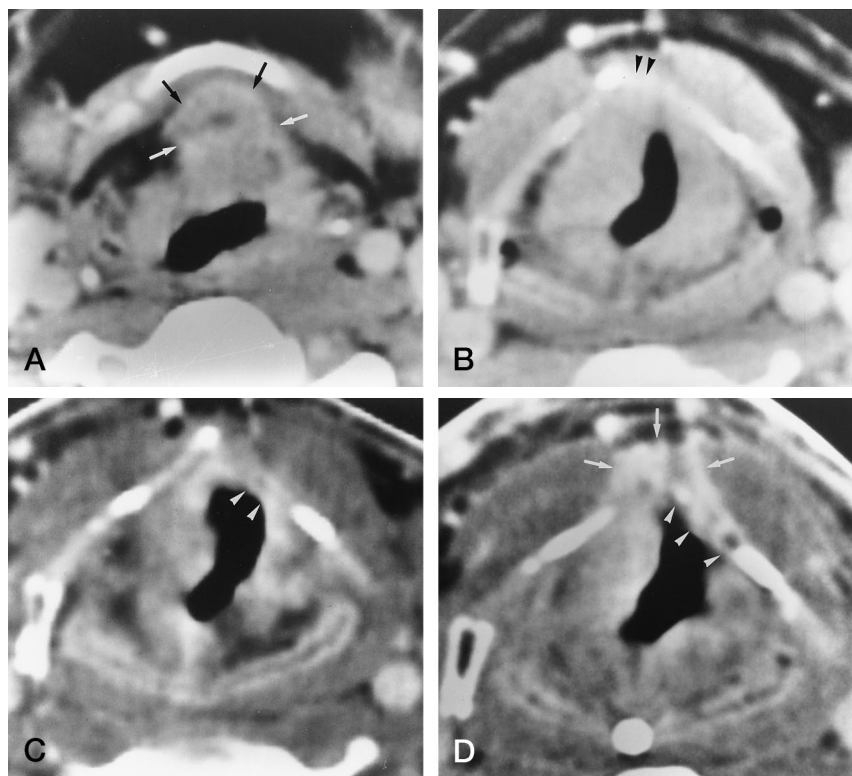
A and B, Pretreatment CT scan in a patient with a T3N1 supraglottic carcinoma (B) was obtained 5 mm below A. Tumor is seen growing into the preepiglottic space (arrows) and over the upper margin of the thyroid cartilage notch (arrowheads).
